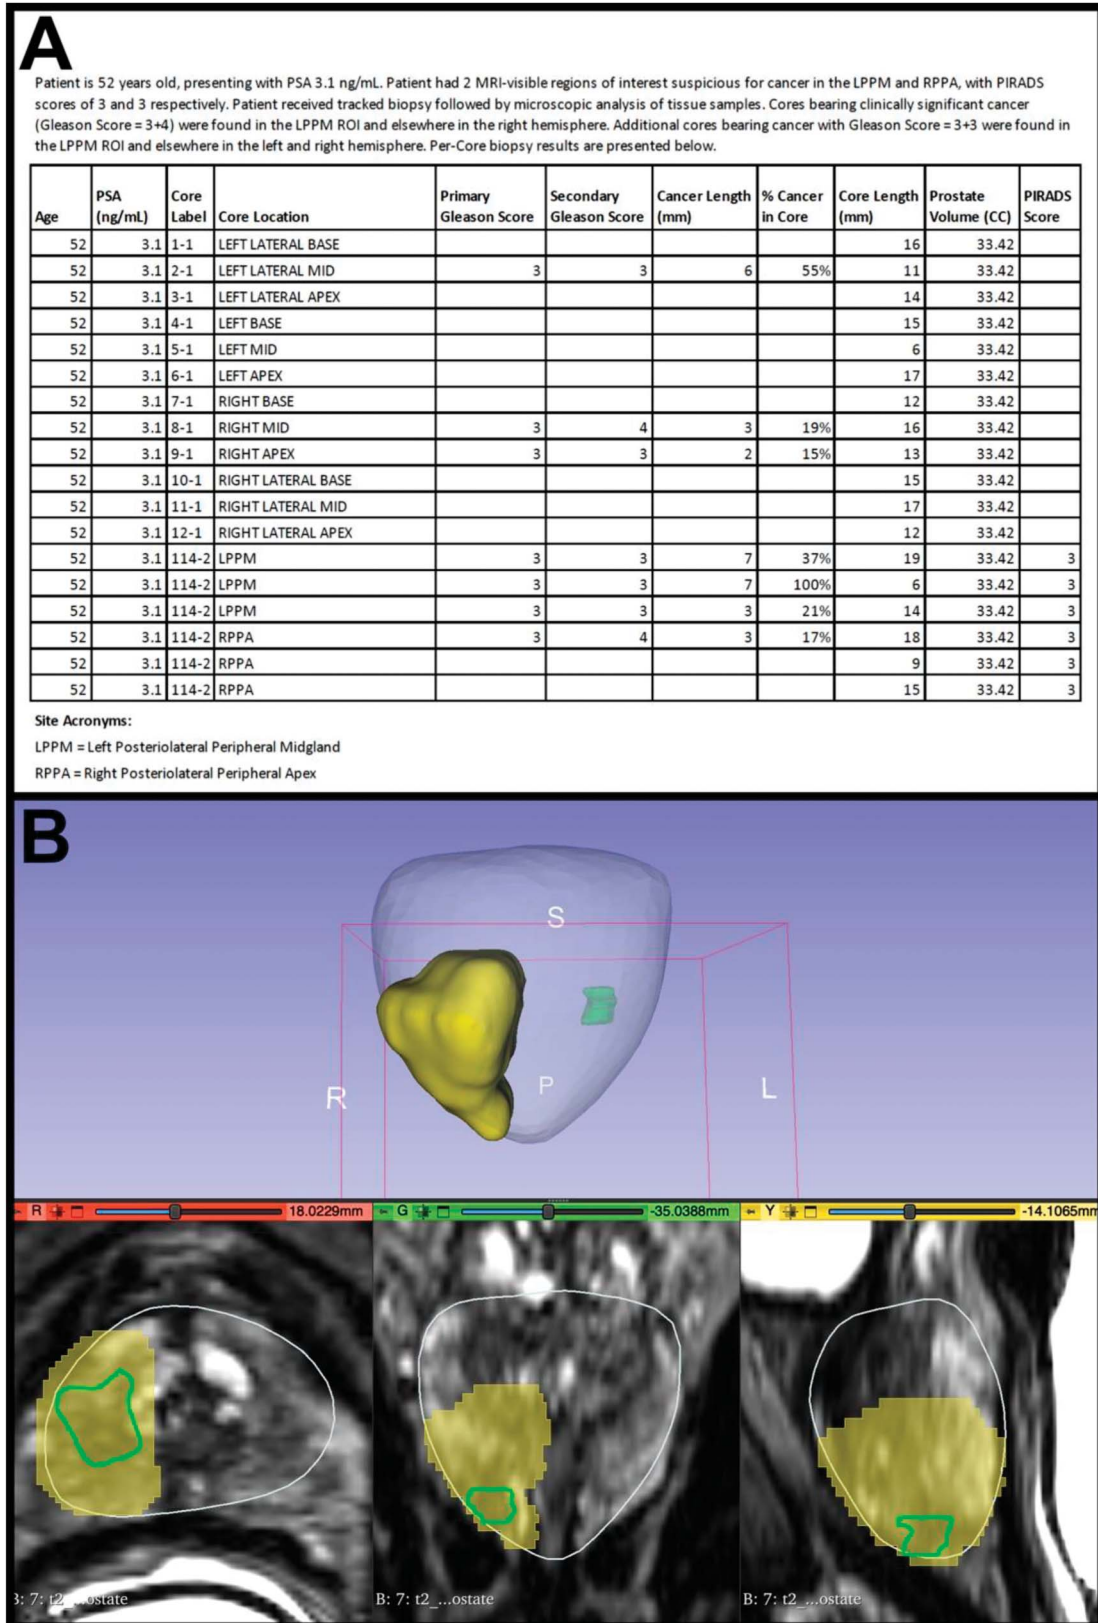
Exemplary image showing the prediction of cancer extent using standard-of-care (SOC) methodology. A, Biopsy pathology summary document. First, a text summary of the case is presented including serum PSA, followed by a table with 1 row per biopsy core. B, 3D Slicer software showing 3D surfaces (top) and scrollable T2-weighted MRI in axial, coronal, and sagittal views (bottom). The prostate surface model is shown in white, Prostate Imaging Reporting and Data System (PIRADS) regions of interest suspicious for prostate cancer are shown in green, and an exemplary manually-drawn SOC cancer contour is shown in yellow.
